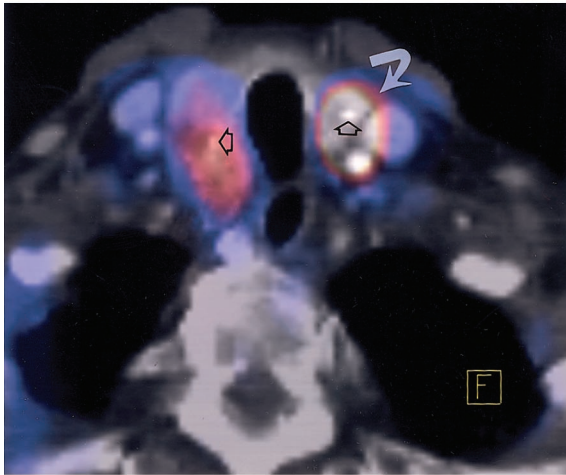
(15) Laryngeal carcinoma in an 80-year-old man who underwent FDG PET-CT to characterize a new pulmonary nodule in the left upper lobe. (a) Axial fused FDG PET-CT image of the pulmonary nodule shows intense hypermetabolism (arrow), which was due to metastatic squamous cell carcinoma at wedge resection. (b) Axial CT image of the neck shows nonspecific bilateral thyroid nodules (solid arrows) with foci of calcification (open arrows), which were incidentally noted and are suggestive of multinodular goiter. (c) Corresponding fused FDG PET-CT image shows intense hypermetabolism in the left-sided thyroid nodule (curved arrow). Total thyroidectomy revealed left-sided papillary thyroid carcinoma and right-sided multinodular goiter. Open arrows = foci of calcification. (16) Biopsy-proved poorly differentiated non-small cell carcinoma in the native left lung in a 56-year-old man with idiopathic pulmonary fibrosis and a right lung transplant. (a) Axial CT image shows a large, conglomerate pulmonary mass in the left lower lobe (straight arrow) with enlargement of a subcarinal lymph node (curved arrow). (b) Corresponding fused FDG PET-CT image shows intense hypermetabolism in the mass (straight arrow) and the metastatic node (curved arrow).
